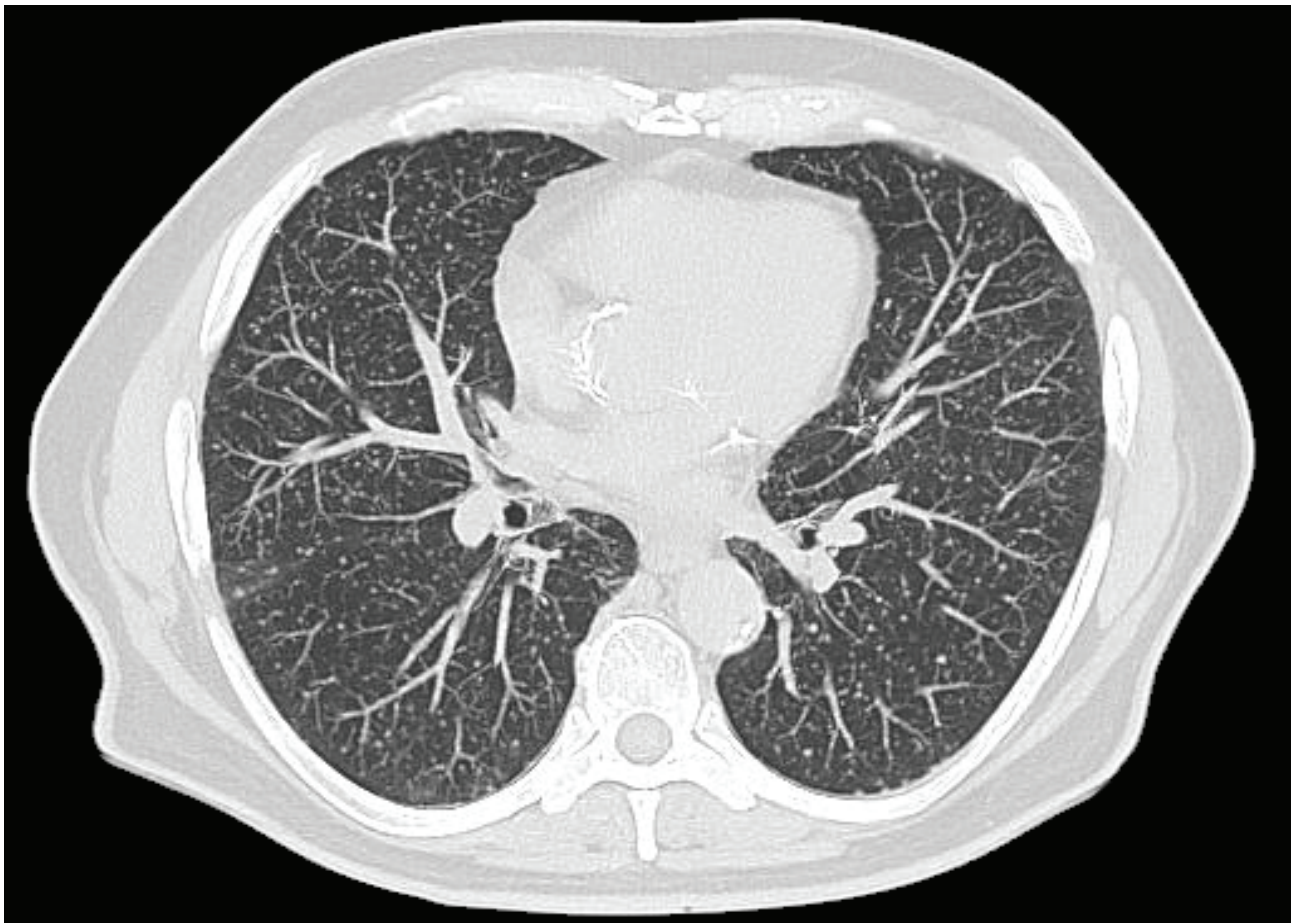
Computed tomography scan showing pulmonary nodules in a miliary pattern
